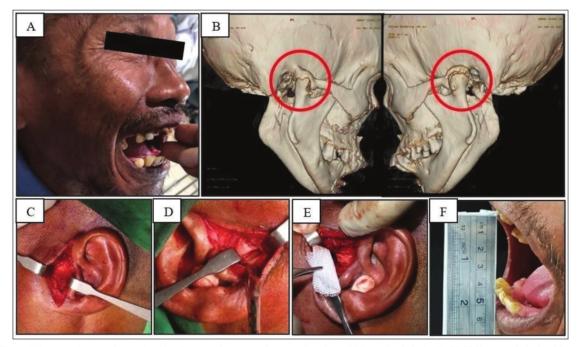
Preoperative mouth opening (A), Computed tomography-scan view showed bilateral ankylosis (B), TMJ fibrous ankylosis with ankylosing bone formation (C), gap arthroplasty (D), interpositional arthroplasty with Mersilene mesh (E), 3 months post-operative mouth opening (F)
